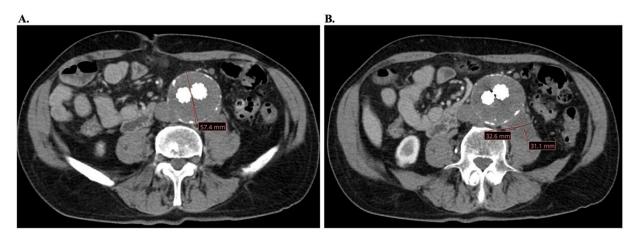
(A) CT imaging demonstrating stable aorto-iliac vascular Endo graft with a lumen of 5.7 cm. Absence of graft leak and/or fistulizing tract to the vascular graft. (B) A fluid collection of 3.2 x 3.1 cm is visualized adjacent to the Endo graft. Absence of air within the vascular graft or iliopsoas muscle. T1, T2, T1.
